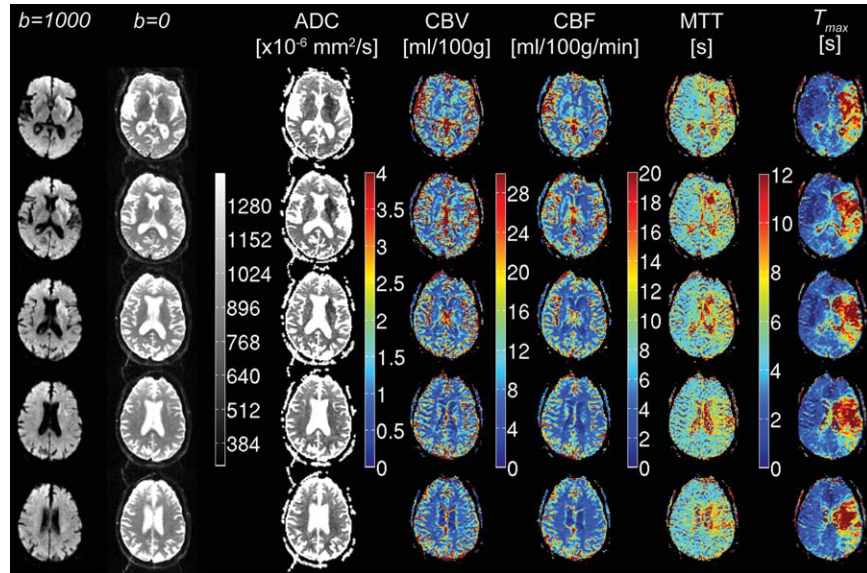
Example of spatially coregistered DWI and PWI datasets. From left to right: $S_{b=1000}$ (“isotropic” diffusion), $S_{b=0}$ (diffusion-weighting gradients turned off = T_2 -weighted data), apparent diffusion coefficient (ADC), cerebral blood volume (CBV), cerebral blood flow (CBF), mean transit time (MTT), and T_{max} . The $S_{b=1000}$ and ADC images are used to identify the stroke core, whereas abnormalities on T_{max} and MTT maps indicate hypoperfused tissue. The CBF maps reflect hypoperfusion as well (bottom row), but differences between CBF in gray and white matter and the smaller dynamic range render these maps less conspicuous than maps of temporal perfusion parameters.
